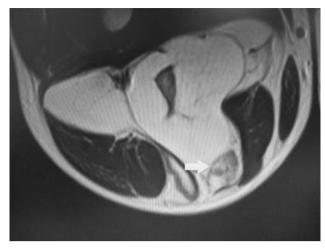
Example of a nodule. The image presents a case of lipoma in the thigh of a 48-year-old male patient. A non-fatty nodule was detected in the T1-weighted image (white arrow).
